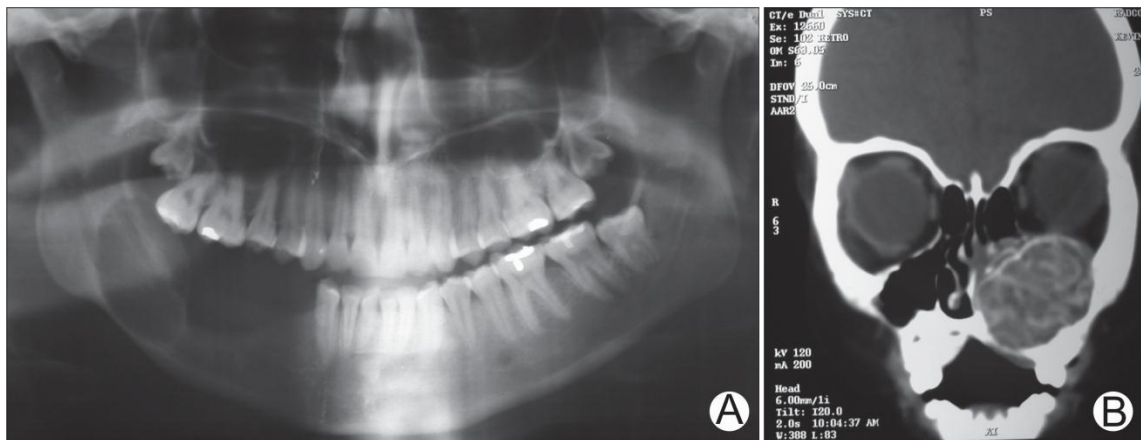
A. Image features case 5. Panoramic radiography showing a radiolucent and well demarcated lesion in the angle and ramus of the left mandible. B. Image features of case 4. Computerized tomography, coronal view. Mixed hypodense/ hyperdense image showing well delimited margins exhibiting expansion of the left maxilla and maxillary sinus.
